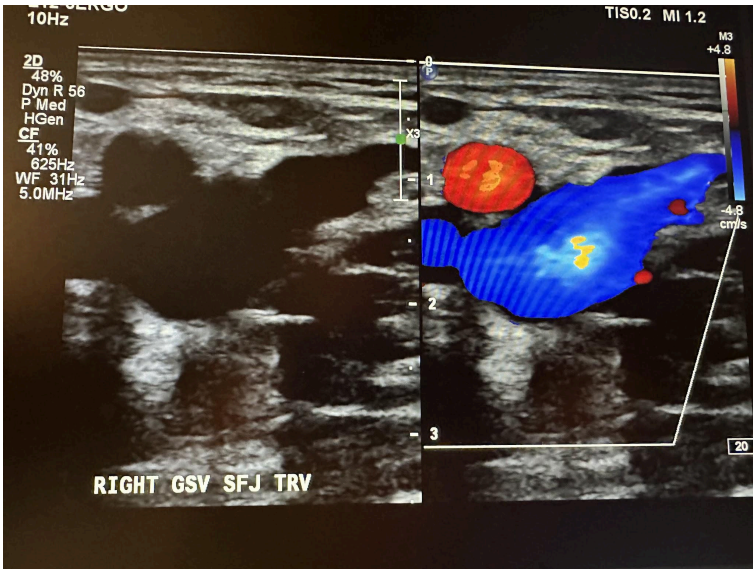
Side-by-side right great saphenous vein at the saphenofemoral junction transverse view without and with color Doppler.
